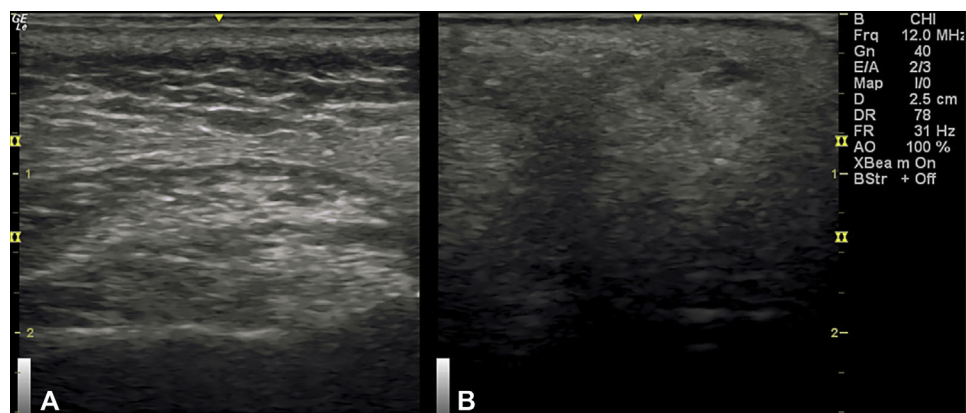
Ultrasonographic findings in the normal nonindurated skin (A), and in indurated skin at 6 months after the start of isotretinoin treatment (B).
